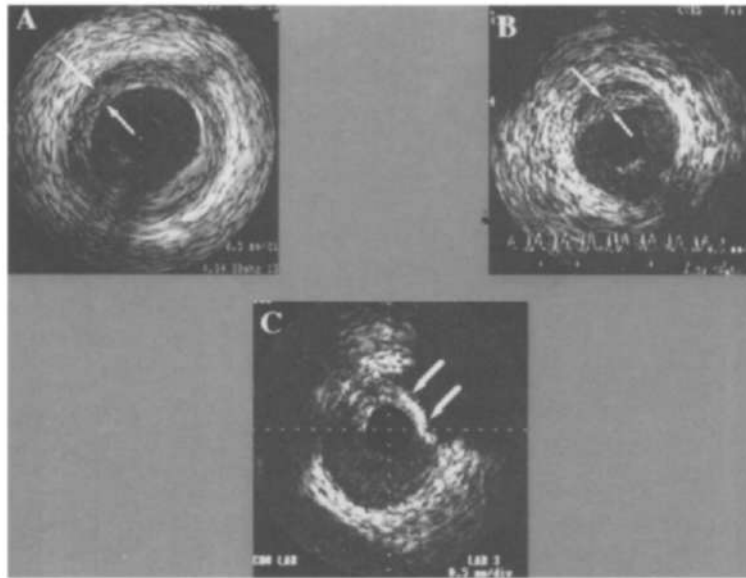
Intracoronary ultrasound images show characteristics of intimal thickening in transplant coronary artery disease definable by this method. *Black circle in center (calibration dots at intervals of 0.5 mm) of each ultrasound image is imaging catheter. Circular lumen is slightly less black. Circumferentially nonuniform soft gray shadow of intimal thickening (small arrows) is outlined by darker stripe of more echolucent medial layer in panels A and B. A, Concentric severe lesion; B, eccentric severe lesion; C, eccentric and calcified lesion. Large arrows indicate eccentric area with bright echoes from intima associated with acoustic shadowing beyond plaque. Acoustic shadowing is characteristic of calcium within lesion. White streak near catheter with fuzziness beyond shown in panels A (7 o'clock), B (5 o'clock) and C (10 o'clock) is due to structure of imaging catheter.*
